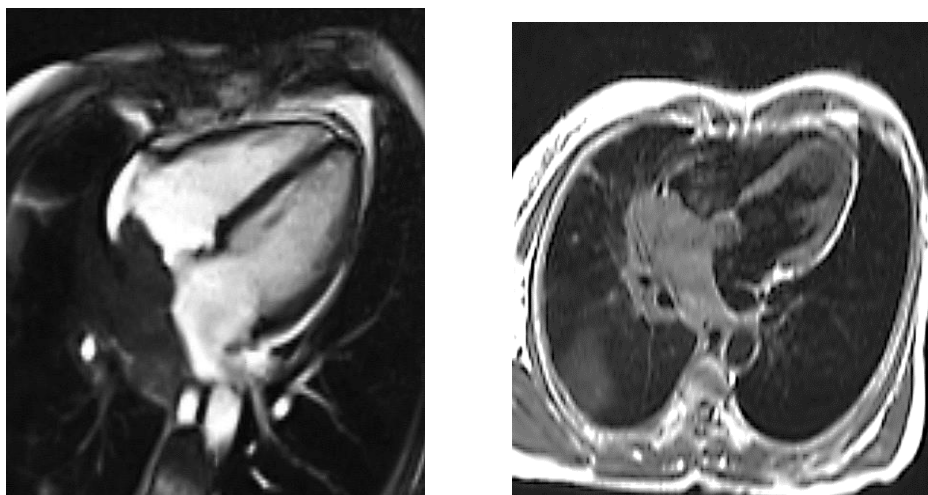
MRI shows case of epithelioid hemangioendothelioma infiltrating the posterior walls of RA and LA across the interatrial septum and pericardium
